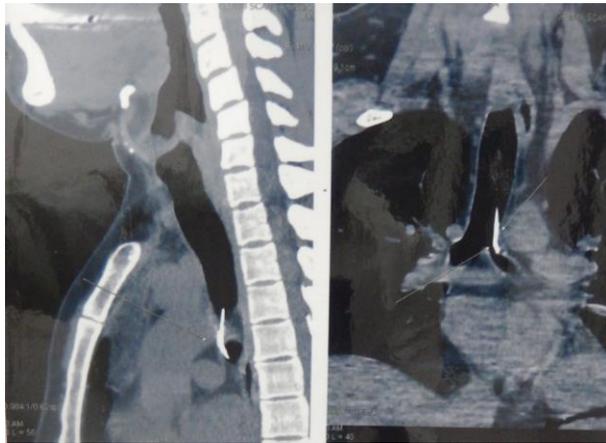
5b CT tracing needle at left bronchus
